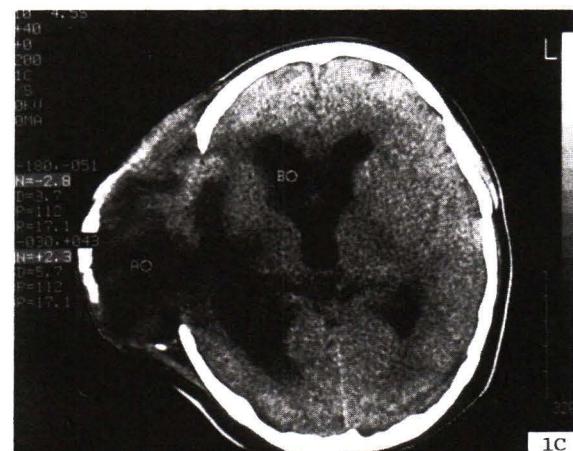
Fig. 1A was the first CT scan done on December 8, 1993 showing thin acute subdural hematoma at the right parietal area and right hemispheric swelling. The midline was shifted to the left 5.4 mm. Due to the patient's clinical signs and symptoms of uncal herniation, an emergency craniotomy was performed to remove the hematoma. During the clot removal, the brain was bulging severely from the craniotomy site. Decompressed craniectomy was done for closure enhancement. Fig. 1B was the immediate postoperative CT scan showing contralateral epidural hematoma. Fig. 1C was the CT scan done 8 months after the time of head injury showing severe hydrocephalus. Third ventricle and temporal horns were enlarged. Sulci were not seen.
